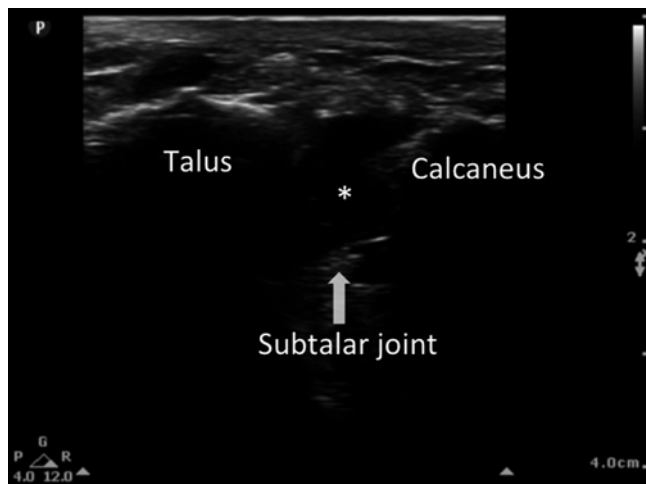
Sonogram shows the pooling of injectate (*) following injection (Reproduced with permission from Philip Peng Educational Series)
